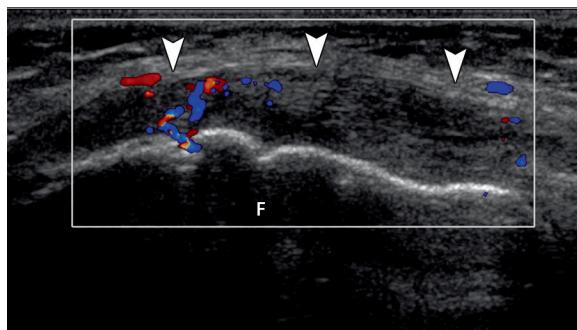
Prepatellar bursitis on US images obtained at the midline, along the long axis of the patella. (a) Ill-defined hypoechoic thickening (arrowheads) of the prepatellar bursa, best appreciated when using abundant surrounding gel and minimal transducer pressure. (b) Complex fluid (arrowheads) within the superficial infrapatellar bursa. (c, d) Radiograph (c) and US image (d) demonstrate gas (arrowheads) within a thickened prepatellar bursa. The presence of gas may indicate infection. Gas generates hyperechoic foci at US with posterior acoustic shadowing.
